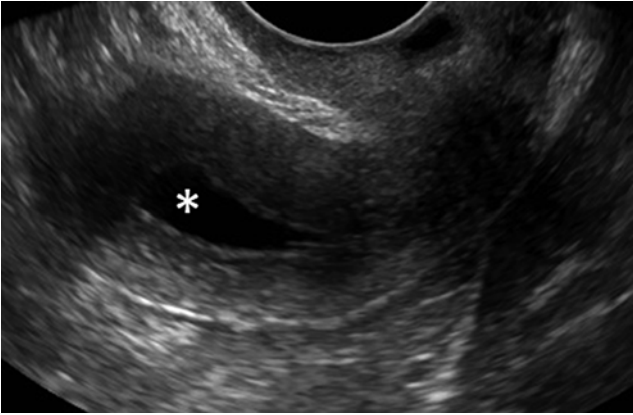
Hematometra. Transvaginal ultrasound showing hematometra, indicated with an *asterisk* (*), and a thin endometrial lining
